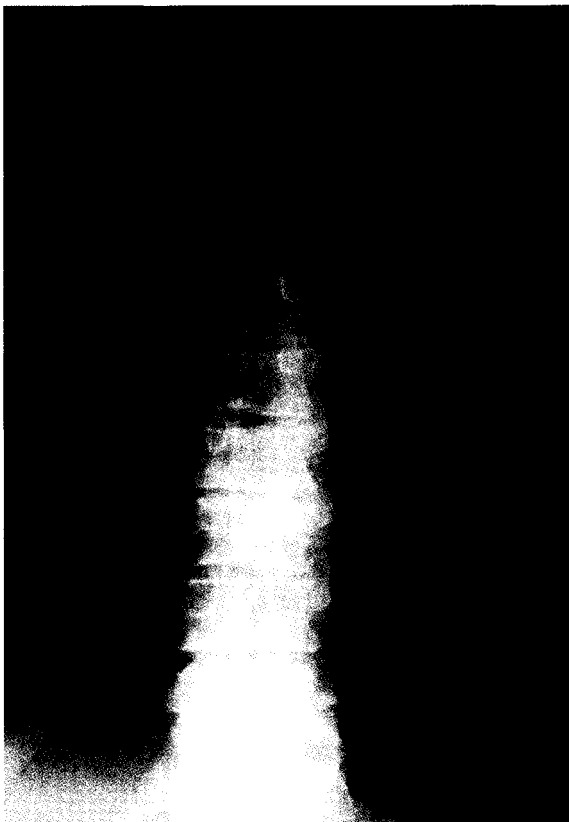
Plain radiograph of thoracic spine, showing arch-like (Th 9-10) and beak-like (Th11-12) bridging syndesmophytes.
